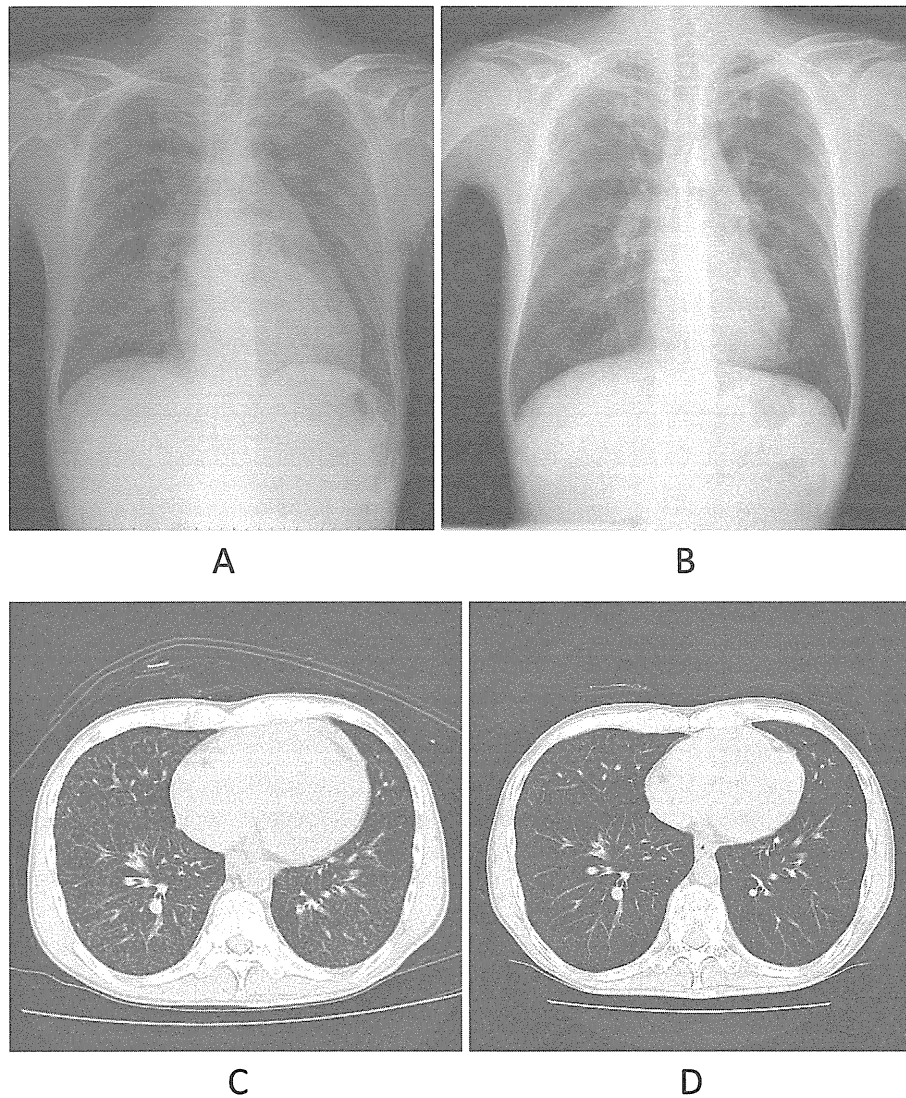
Chest X-ray and high-resolution computed tomography (HRCT) before and after imatinib treatment. A: A chest X-ray obtained before imatinib treatment showed dilation of the pulmonary artery trunk and cardiomegaly. B: A chest X-ray obtained after imatinib treatment showed improvements in the dilation of the pulmonary artery trunk and cardiomegaly. C: HRCT performed before imatinib treatment showed diffuse bilateral centrilobular ground glass opacity and septal thickening. D: HRCT performed after three months of imatinib treatment. The ground glass opacity and septal thickening had improved, and the pericardial effusion had decreased.
